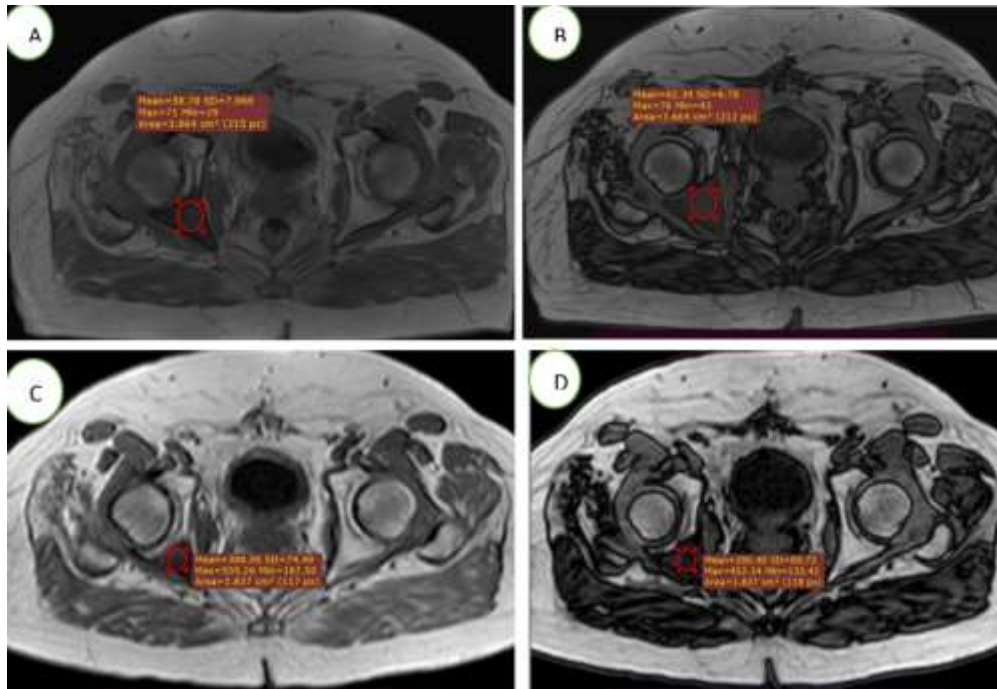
Axial images of 46-year-old man with prostatic cancer. A) axial IP Dixon image before therapy B) OP image before therapy, C) axial IP Dixon image after radiotherapy follow up after 4 months D) axial OP Dixon image after radiotherapy % drop in 1st study= -7.9% (consistent with malignant bone marrow replacing lesion... metastasis) and in 2nd study= 25.2% denoting good response to treatment confirmed by PET CT.
